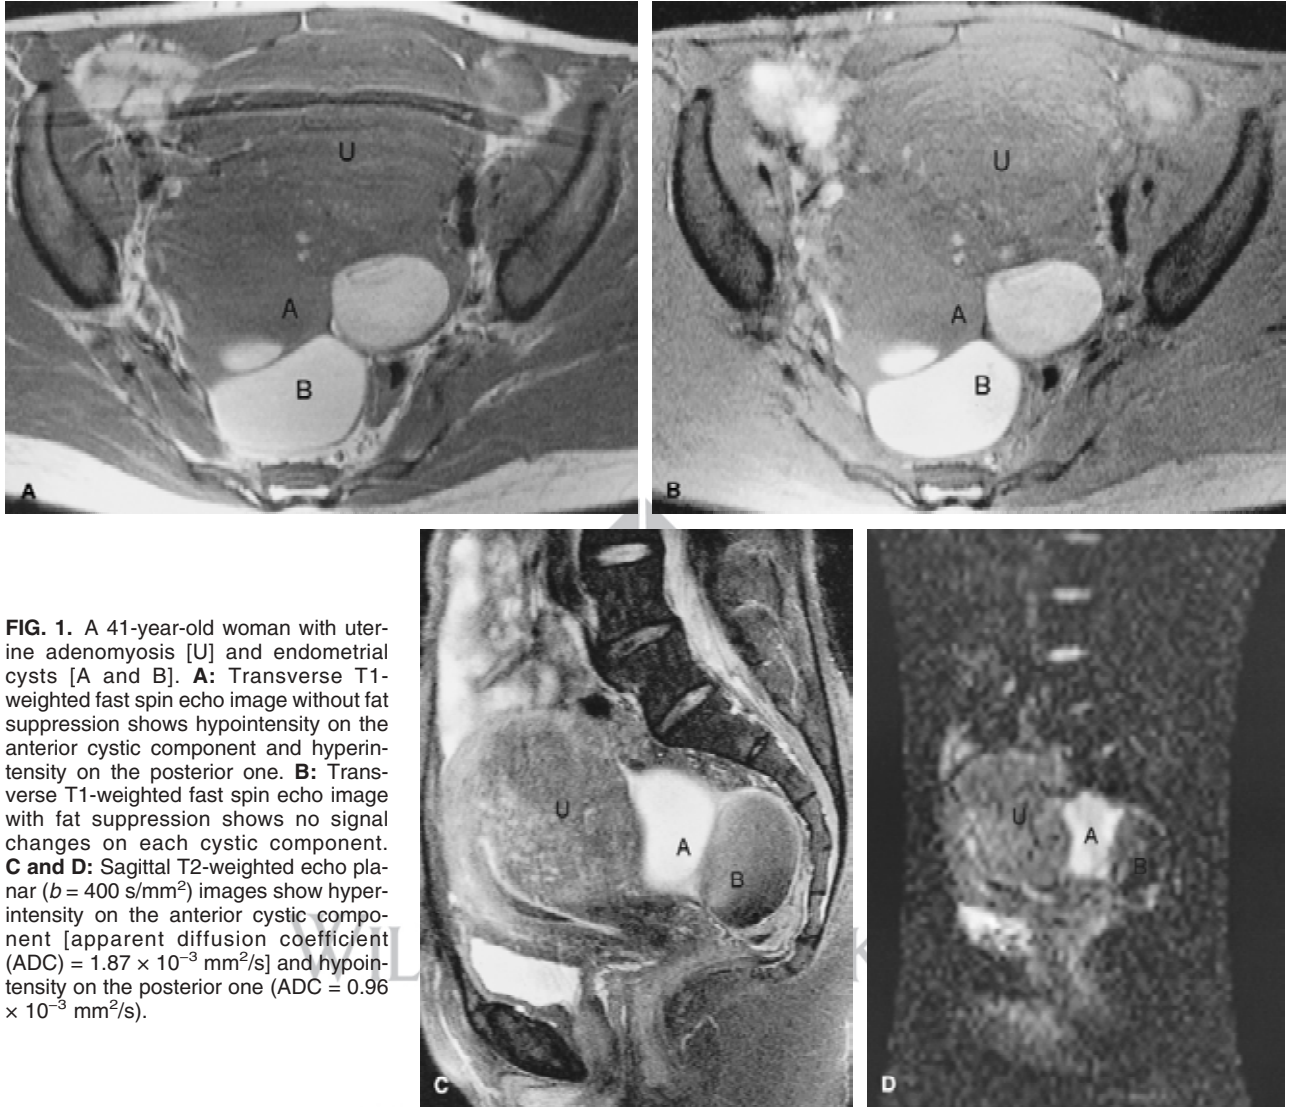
A 41-year-old woman with uterine adenomyosis [U] and endometrial cysts [A and B]. A: Transverse T1-weighted fast spin echo image without fat suppression shows hypointensity on the anterior cystic component and hyperintensity on the posterior one. B: Transverse T1-weighted fast spin echo image with fat suppression shows no signal changes on each cystic component. C and D: Sagittal T2-weighted echo planar ($b = 400 \text{ s/mm}^2$) images show hyperintensity on the anterior cystic component [apparent diffusion coefficient (ADC) = $1.87 \times 10^{-3} \text{ mm}^2/\text{s}$] and hypointensity on the posterior one (ADC = $0.96 \times 10^{-3} \text{ mm}^2/\text{s}$).
